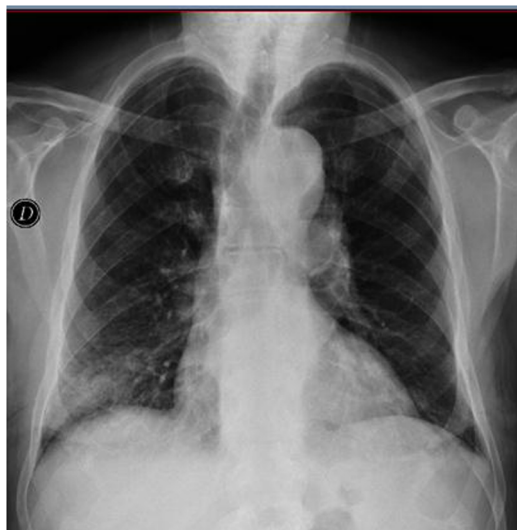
Chest radiograph: consolidation in the right lower lobe (patchy right lower lobe infiltrate).
